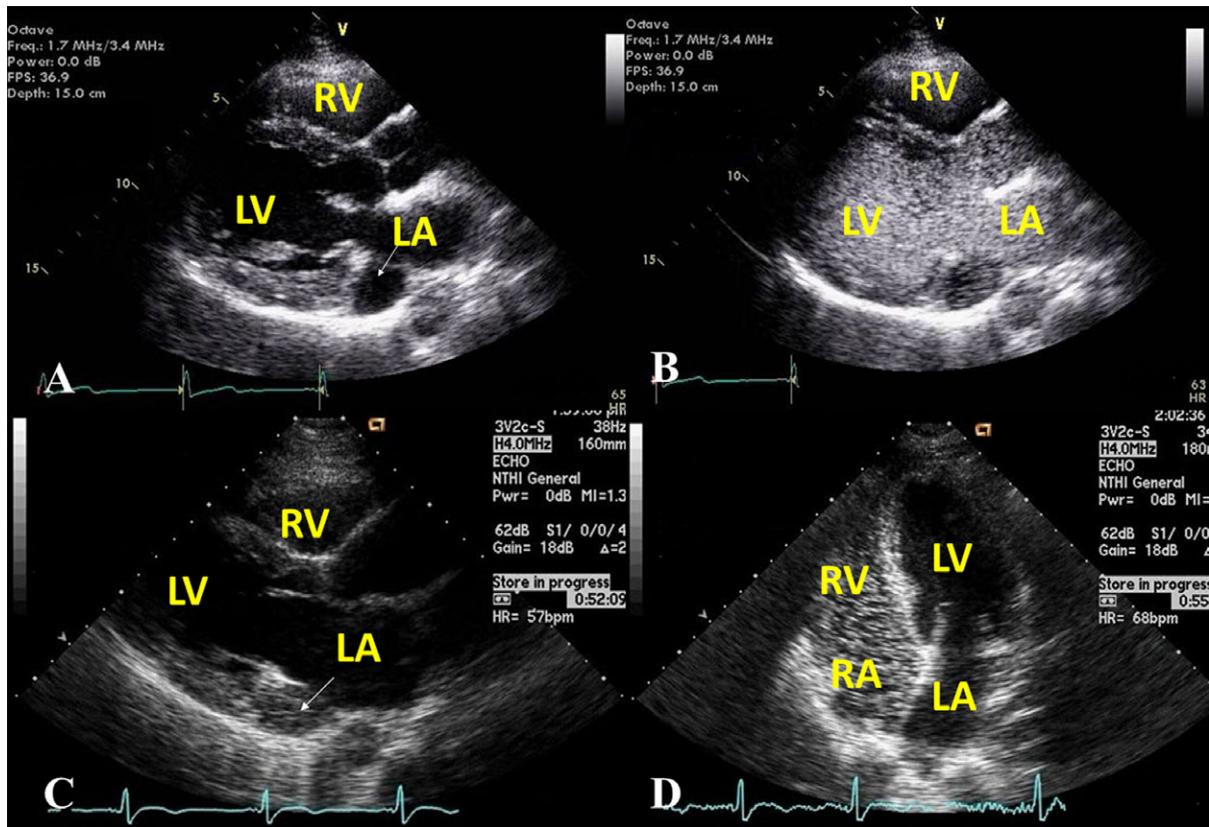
A. Transthoracic echocardiogram in parasternal long-axis view shows floppy coronary sinus (CS) protruding into the mitral valve during ventricular diastole. SCE performed with injection in the left arm and imaging from the subcostal approach shows B. intense filling of right atrium (RA) and right ventricle (RV) through persistent left SVC and dilated CS with C. simultaneous but brief filling of left ventricle (LV) from the partially unroofed CS (C). Ao = aorta; LV = left ventricle.
